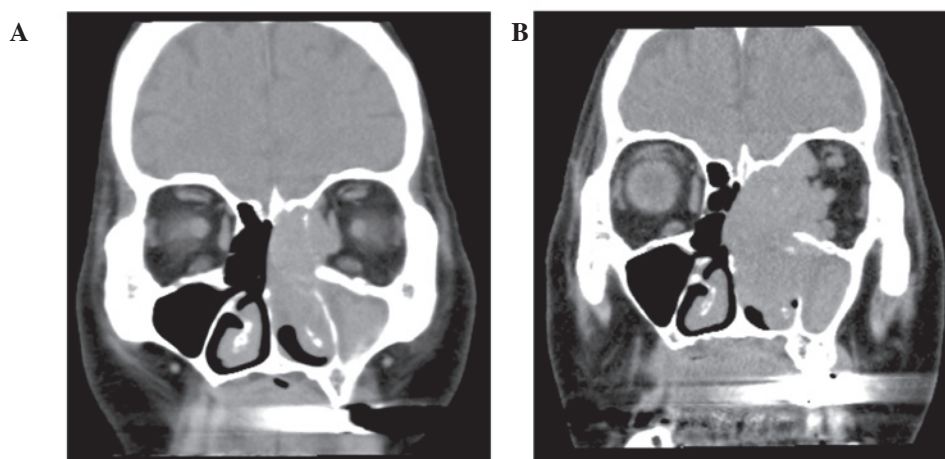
(A) Computed tomography of the head and neck, showing a mass in the left nasal cavity and fluid collection in the paranasal sinus, suggesting paranasal sinusitis. The tumor has invaded to the left orbital cavity. (B) Regrowth of the tumor following shrinkage with heavy ion radiotherapy.
